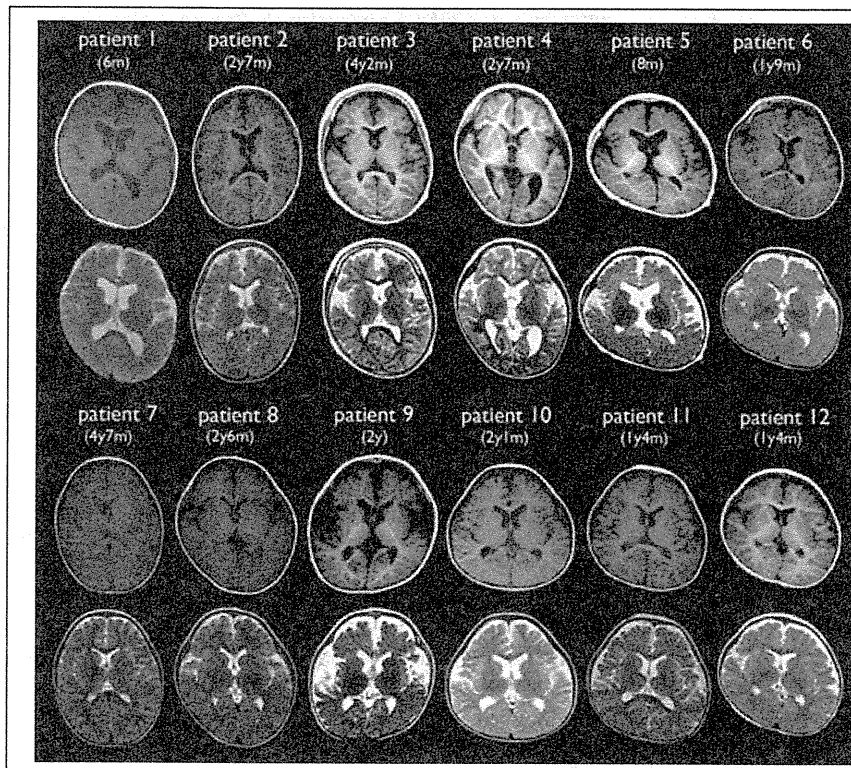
Brain MRI findings of the patients. T₁- (up) and T₂-weighted (bottom) MRI indicates frontal atrophies in many patients, except for Patient 7. In Patient 6, spoiled gradient echo (SPGR) is shown instead of T₁.
